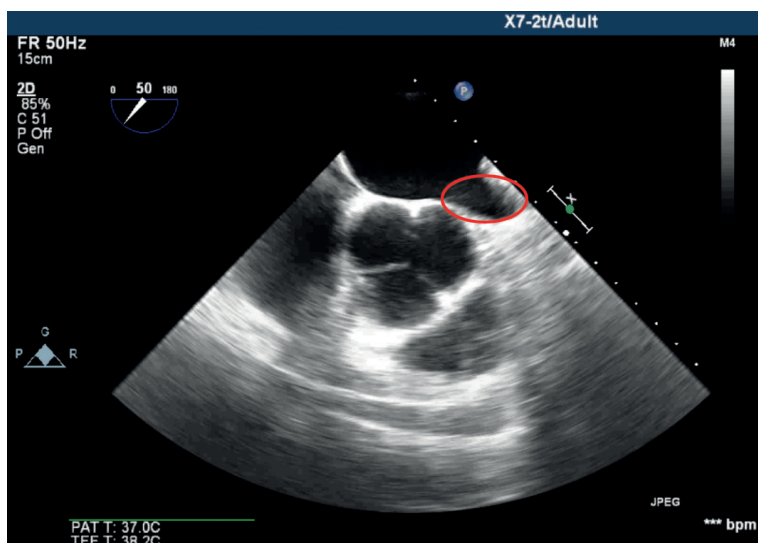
Transesophageal echocardiography after thoracoscopic left atrial appendage amputation. There is an embologenic left atrial appendage stump with a depth of more than 1 cm, its cavity is highlighted by an oval.
